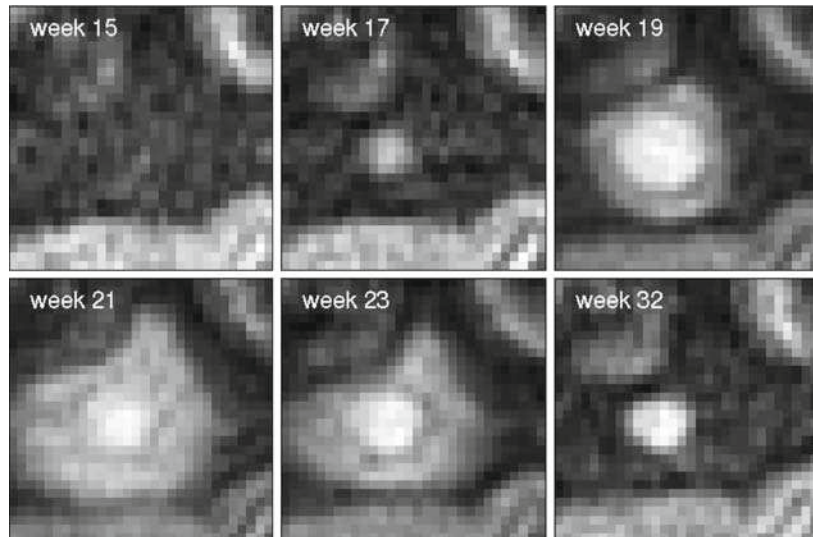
Example of the dynamics of an MS lesion captured in serial T2-weighted MRI. A new lesion appeared in week 17, undergoing rapid edematous changes over the next 5 weeks
